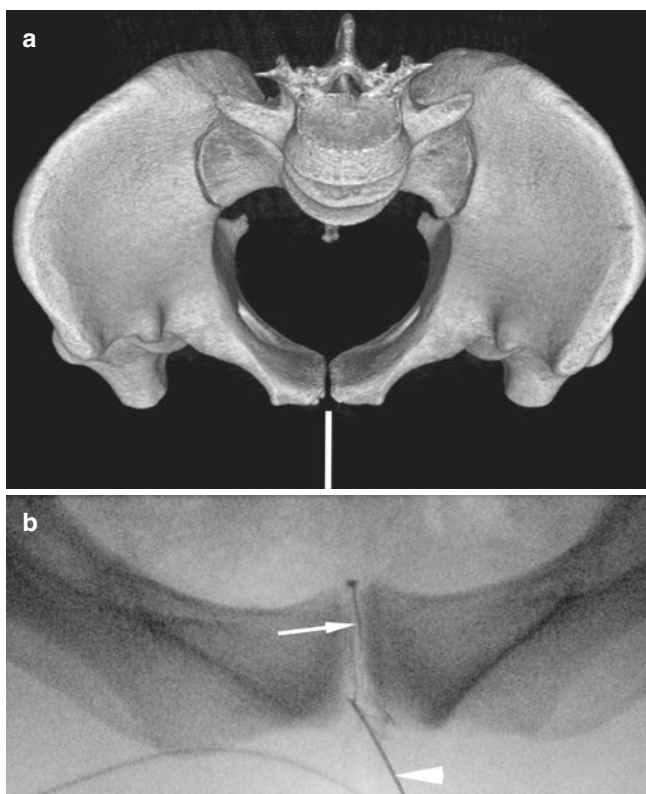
(a) Reconstructed CT pelvis volume viewing the symphysis pubis from above shows the anterior needle approach for fluoroscopic technique. (b) Fluoroscopic image shows needle position (*arrowhead*) in joint with contrast flowing superiorly (*arrow*) through the primary cleft (image courtesy of Prof E. Schilders, London, UK)
